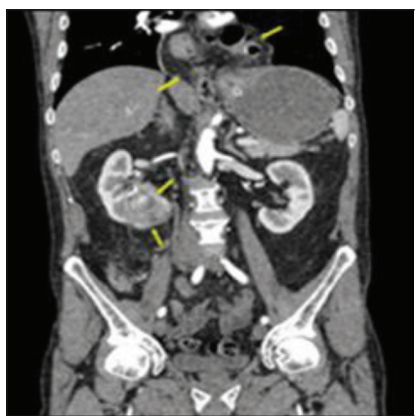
Coronal computed tomography image showing isolated intrathoracic colonic herniation (yellow arrows) and a solitary mass in the right kidney
